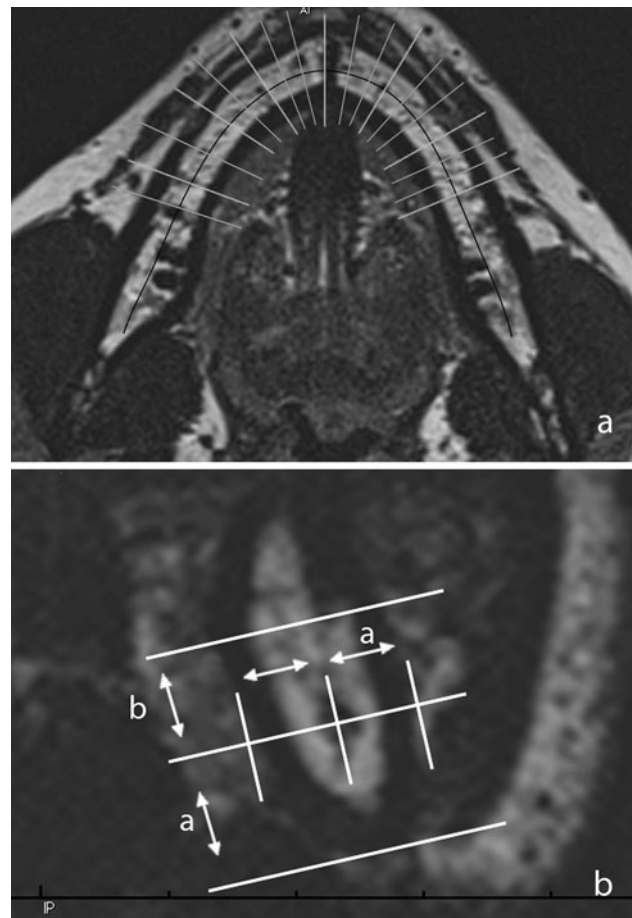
a Axial T2-weighted dental MR SPACE image of the mandible. Planning cross-sectional and panorama view images. b Cross-sectional reconstructed image demonstrating the neurovascular bundle, the cortical bone, and the tooth root. Distance determination of the mandibular canal to the root tip, lingual/buccal/basal cortical plate
